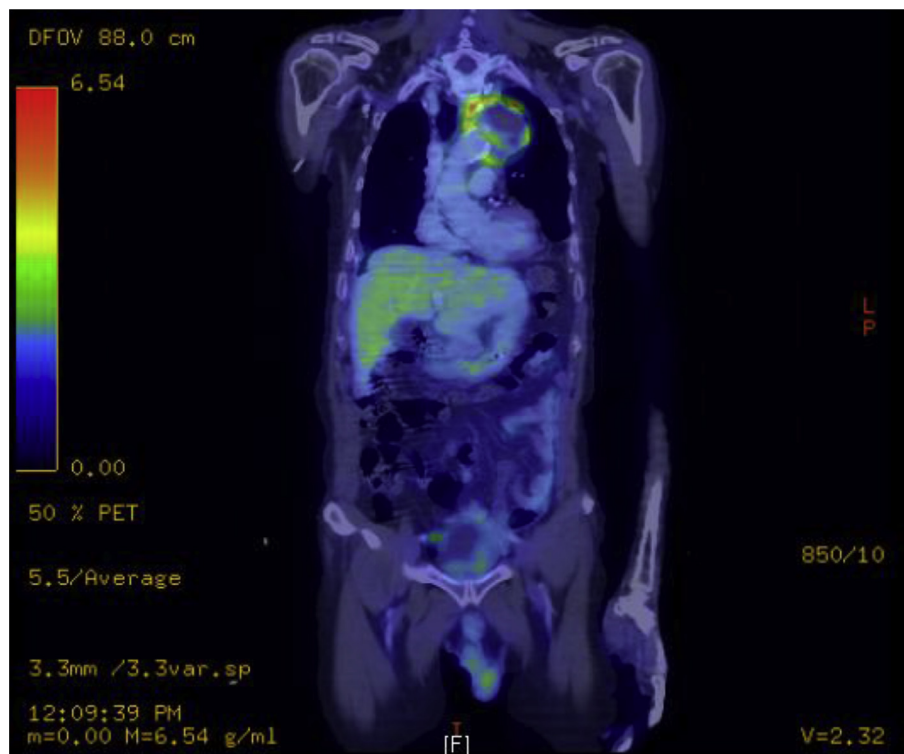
PET-CT showing hypermetabolic mass at the left side of the superior mediastinum, consistent with mycotic aneurysm of the aortic arch/left subclavian artery.
